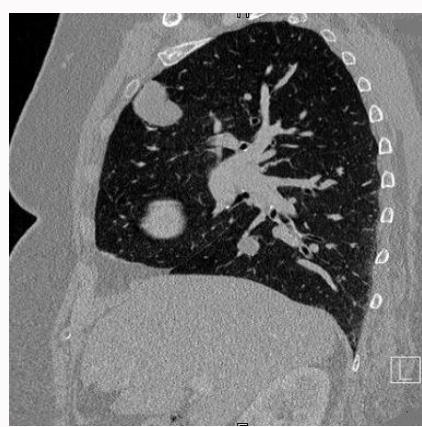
CT scan images.
